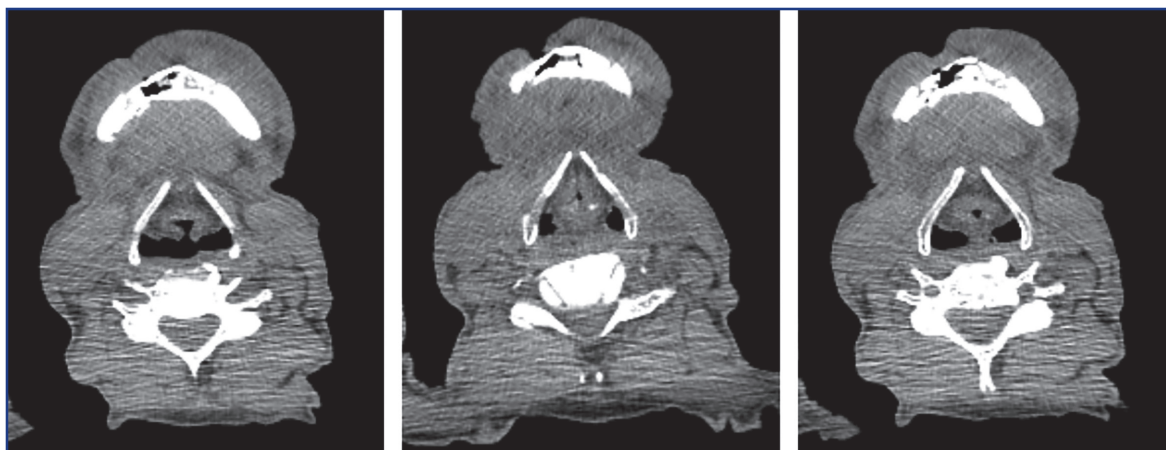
Patient S., born in 1958: a contrast-enhanced CT scan of the mandible and soft tissues of the neck (March 2021)
